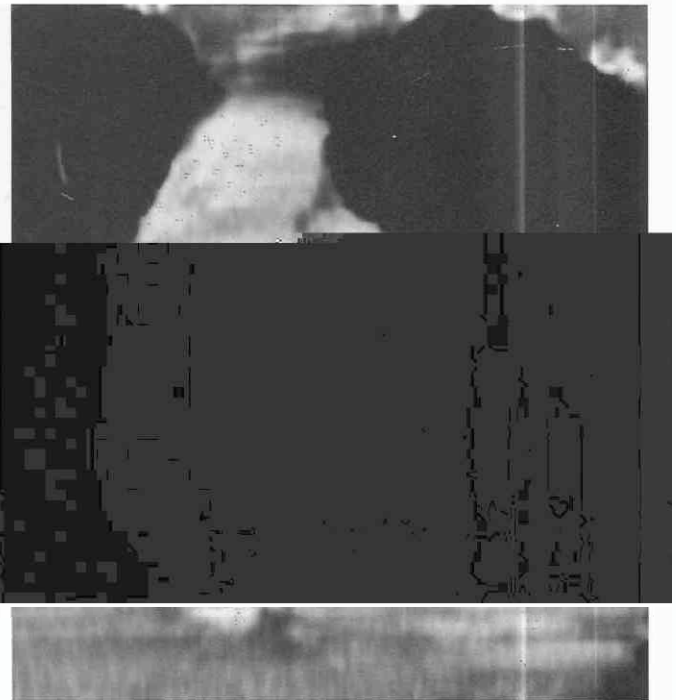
Aortic regurgitation. Coronal multiplanar reformatting image from spiral CT following intravenous contrast medium. There is dilatation of the left ventricle (LV) and aneurysmal dilatation of the ascending aorta (AA), typical findings in patients with aortic regurgitation.
